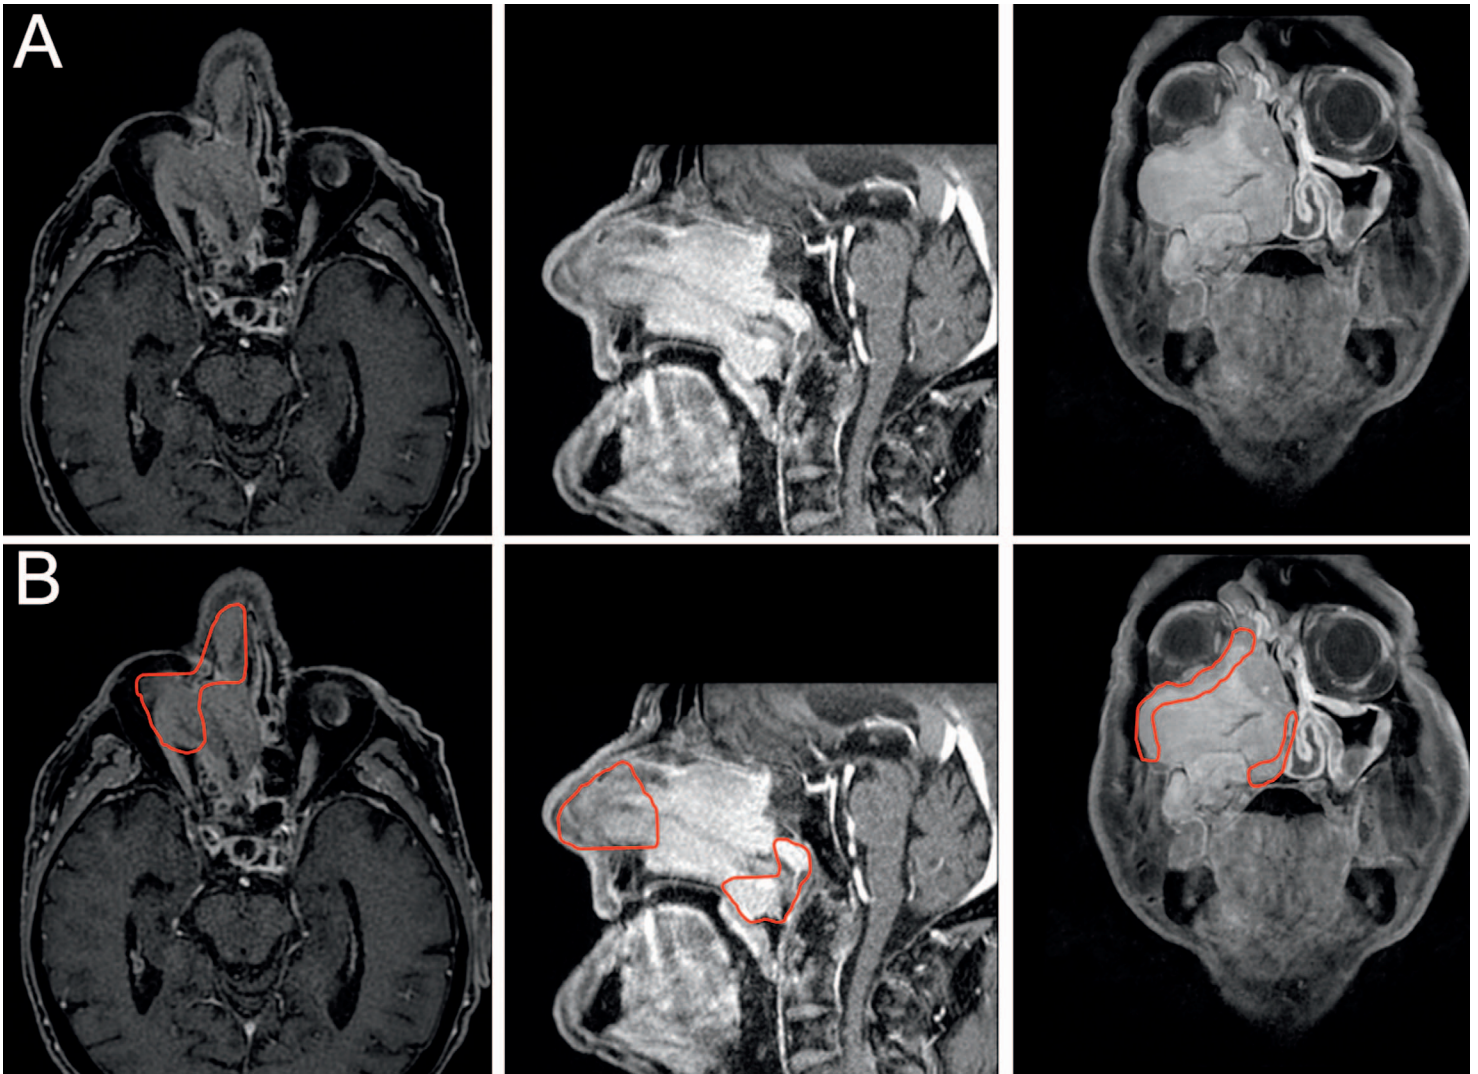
(A) Axial, sagittal, and coronal contrast-enhanced magnetic resonance images taken on October 2015. (B) Areas inside the red lines represent the increase in tumor extension and invasiveness compared with baseline images.
